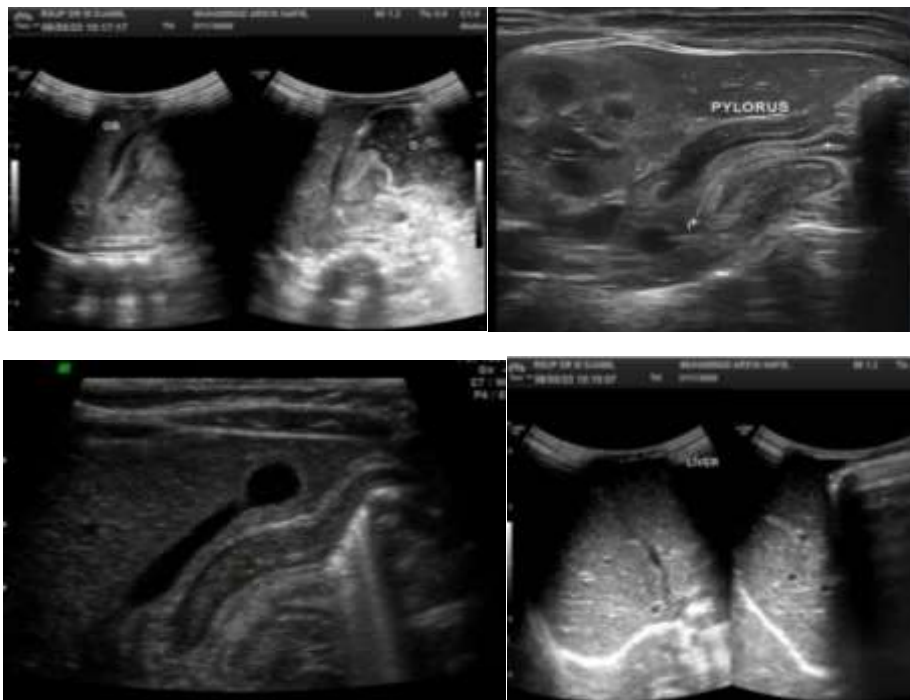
Abdominal Ultrasound (USG) May 10th 2023. Pyloric thickness with antral nipple sign, pylorus length 24.3 mm, with single muscle thickness 8 mm and pyloric thickness 18.7 mm. Hepar, gald bladder, lien: shape and size normal. Pancreas and Aorta: Covered by a dilated gastric shadow. USG: Hypertrophic Pyloric Stenosis.
